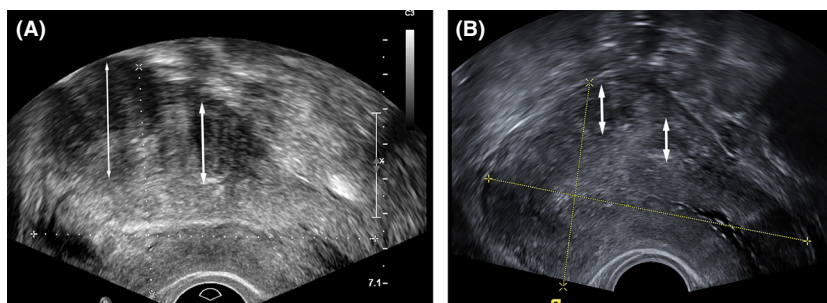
Transvaginal ultrasound, sagittal view of the uterus: two subserosal myomas in the posterior wall. (A) before UPA treatment, (B) after UPA-treatment. UPA, ulipristal acetate.
